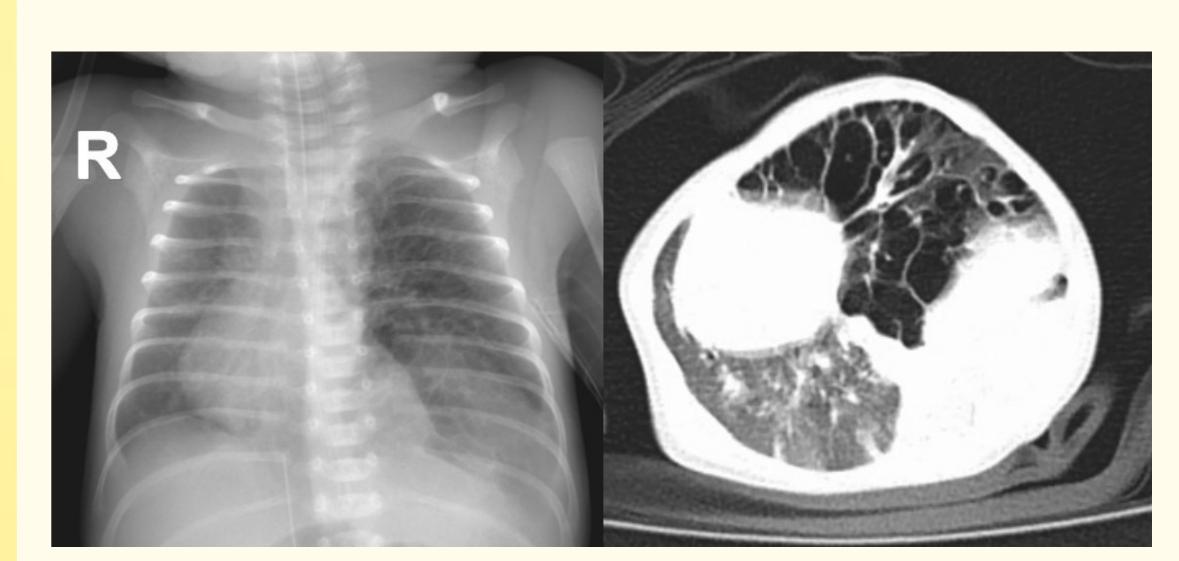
Chest Xray shows hyperaeration on left upper hemithorax which push the mediastinal organ to the right hemithorax (left). CT scan shows multiple bullae on left hemithorax (right).
